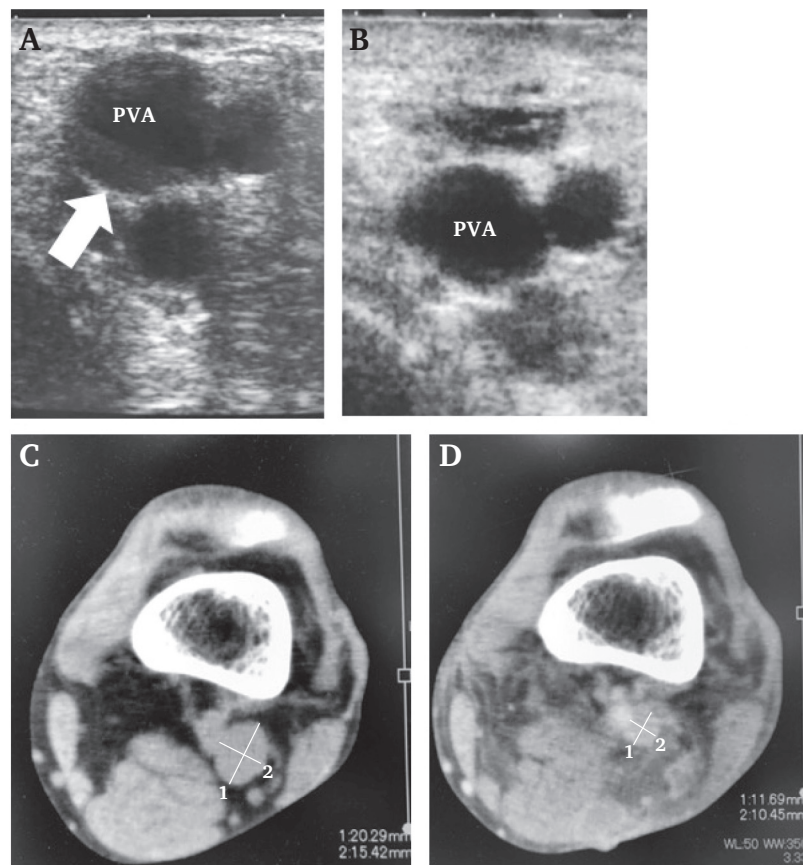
Images of popliteal venous aneurysm. (A) Lower extremity ultrasound in the emergency room. The ultrasound revealed a popliteal venous aneurysm and spontaneous echo contrast (SEC) (arrow mark). There was no spontaneous echo contrast other than in the popliteal venous aneurysm. (B) Ultrasound imaging after treatment. The diameter of the popliteal vein, which had been aneurysmal, had decreased. (C) Plane computed tomography (CT) image before surgery showing a 20 mm diameter saccular popliteal venous aneurysm. SEC was observed on ultrasound, but there was no sign of thrombus on ultrasound imaging. (D) Unenhanced CT after treatment. The diameter was reduced to 11 mm, and SEC was not observed on ultrasound imaging, which suggests improved blood flow in the popliteal vein.
